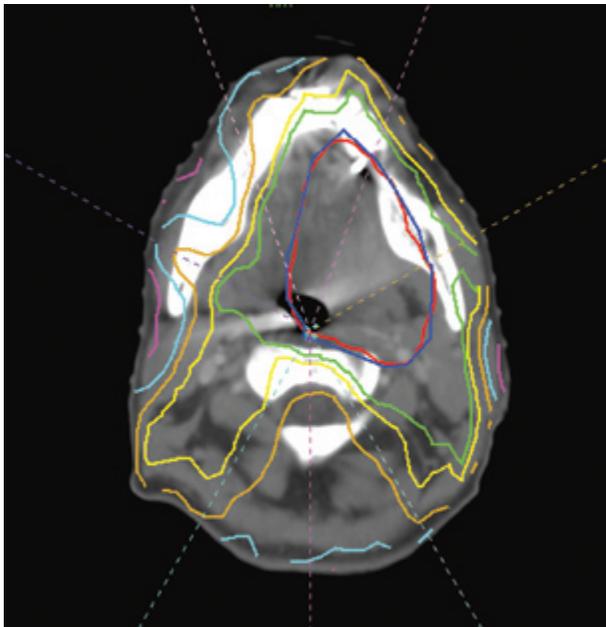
Modern radiation treatment plan using intensity-modulated radiation therapy techniques. The panel shows an axial computed tomography image used to plan radiation delivery for an oropharyngeal tumor. The colored lines represent isodose lines, depicting areas that receive a certain percentage of the radiation dose. These plans spare critical tissues, such as the parotid glands, the toxicities (e.g., xerostomia) of conventional modalities.
